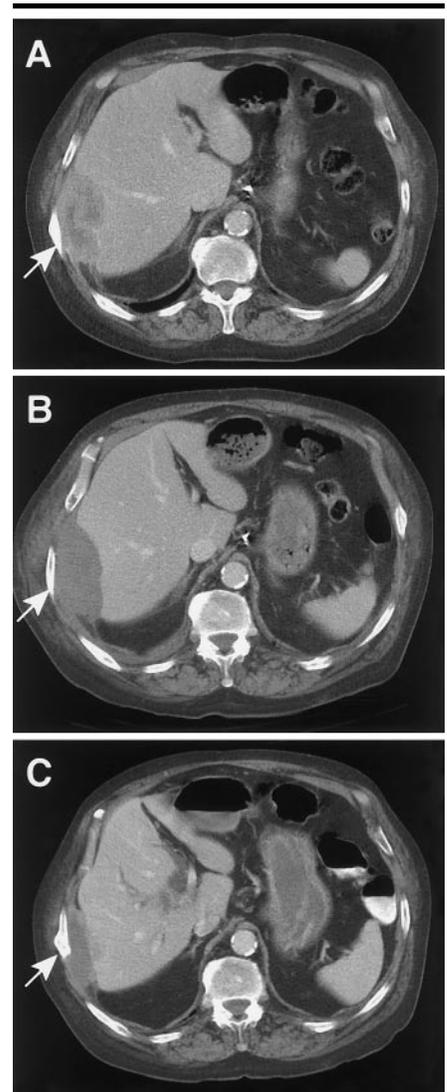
Patient 3. Transverse contrast-enhanced CT images with patient supine show metastatic small cell lung carcinoma lesion (arrows) involving a rib, body wall, and underlying liver. A, Immediately before RF ablation, the mass shows partial enhancement. B, At 1 week after ablation, the mass is hypovascular, which is consistent with necrosis. C, At 12 weeks after ablation, the necrotic mass shows interval decrease in size. Before ablation, the average pain score was 5. At 4, 6, and 8 weeks after ablation, the average pain score was 1. At 6 months after ablation, the reported average pain score was 0.
